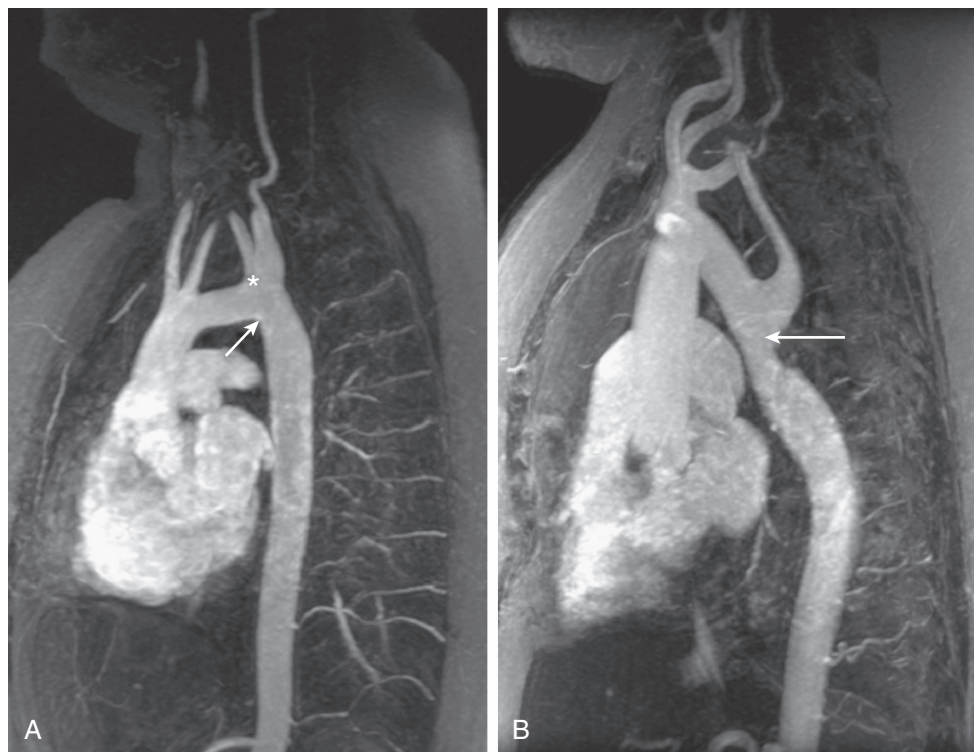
Cardiac magnetic resonance imaging (MRI) aortograms in Turner syndrome. The image on the left (A) shows a squared off, elongated transverse aortic arch (ETA) with a kink in the lesser curvature (arrow). This kink has been called *pseudocoarctation* and is associated with risk for type B dissection. This patient also has a dilated origin of the left subclavian artery (*) and an aberrant origin of the right subclavian artery. The image on the right (B) shows a tortuous aortic arch with coarctation just below the take-off of the left subclavian. There is moderate dilation of the ascending aorta and poststenotic dilation of the descending aorta as well. This image was obtained from a 41-year-old woman with long-standing hypertension who had been followed with cardiac echo over the years.
